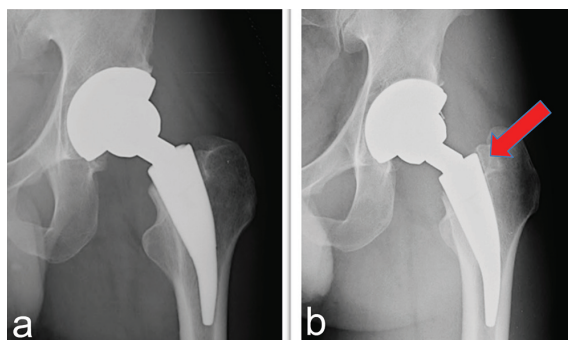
Anteroposterior radiographs of subsiding Metha[®] short stem prosthesis at 12 months postoperatively (b) with radiolucent line at zone 1 compared to initial postoperative (a).
